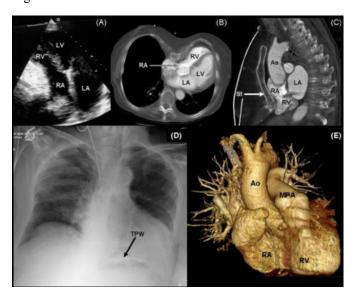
Transthoracic apical 4 chamber echocardiogram highlighting external compression of the right heart.
